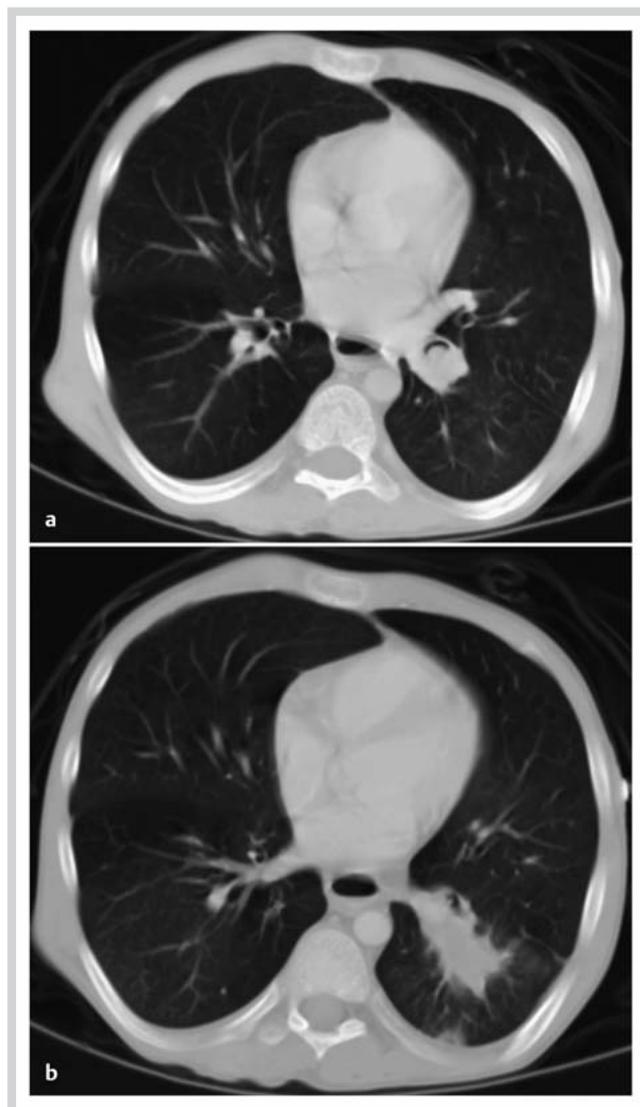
a and b CT scan showing an intrabronchial left inferior hilar mass (a), located in the left lower lobe bronchus, associated with obstruction of the distal airways (b) and pleural thickening (posterobasal segment of the left lower lobe).
